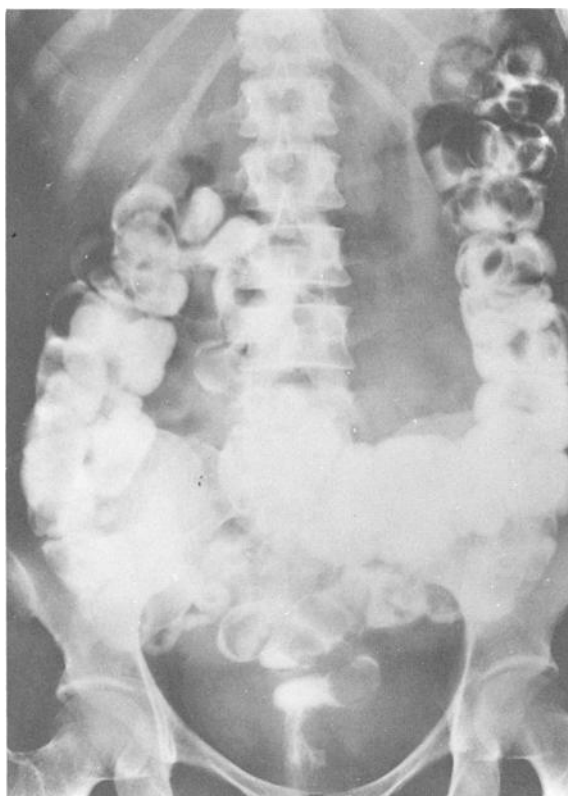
Roentgenogram performed 15 h after the administration of 50 mL of water-soluble contrast compound. Eighty-five packages remained to be eliminated.
